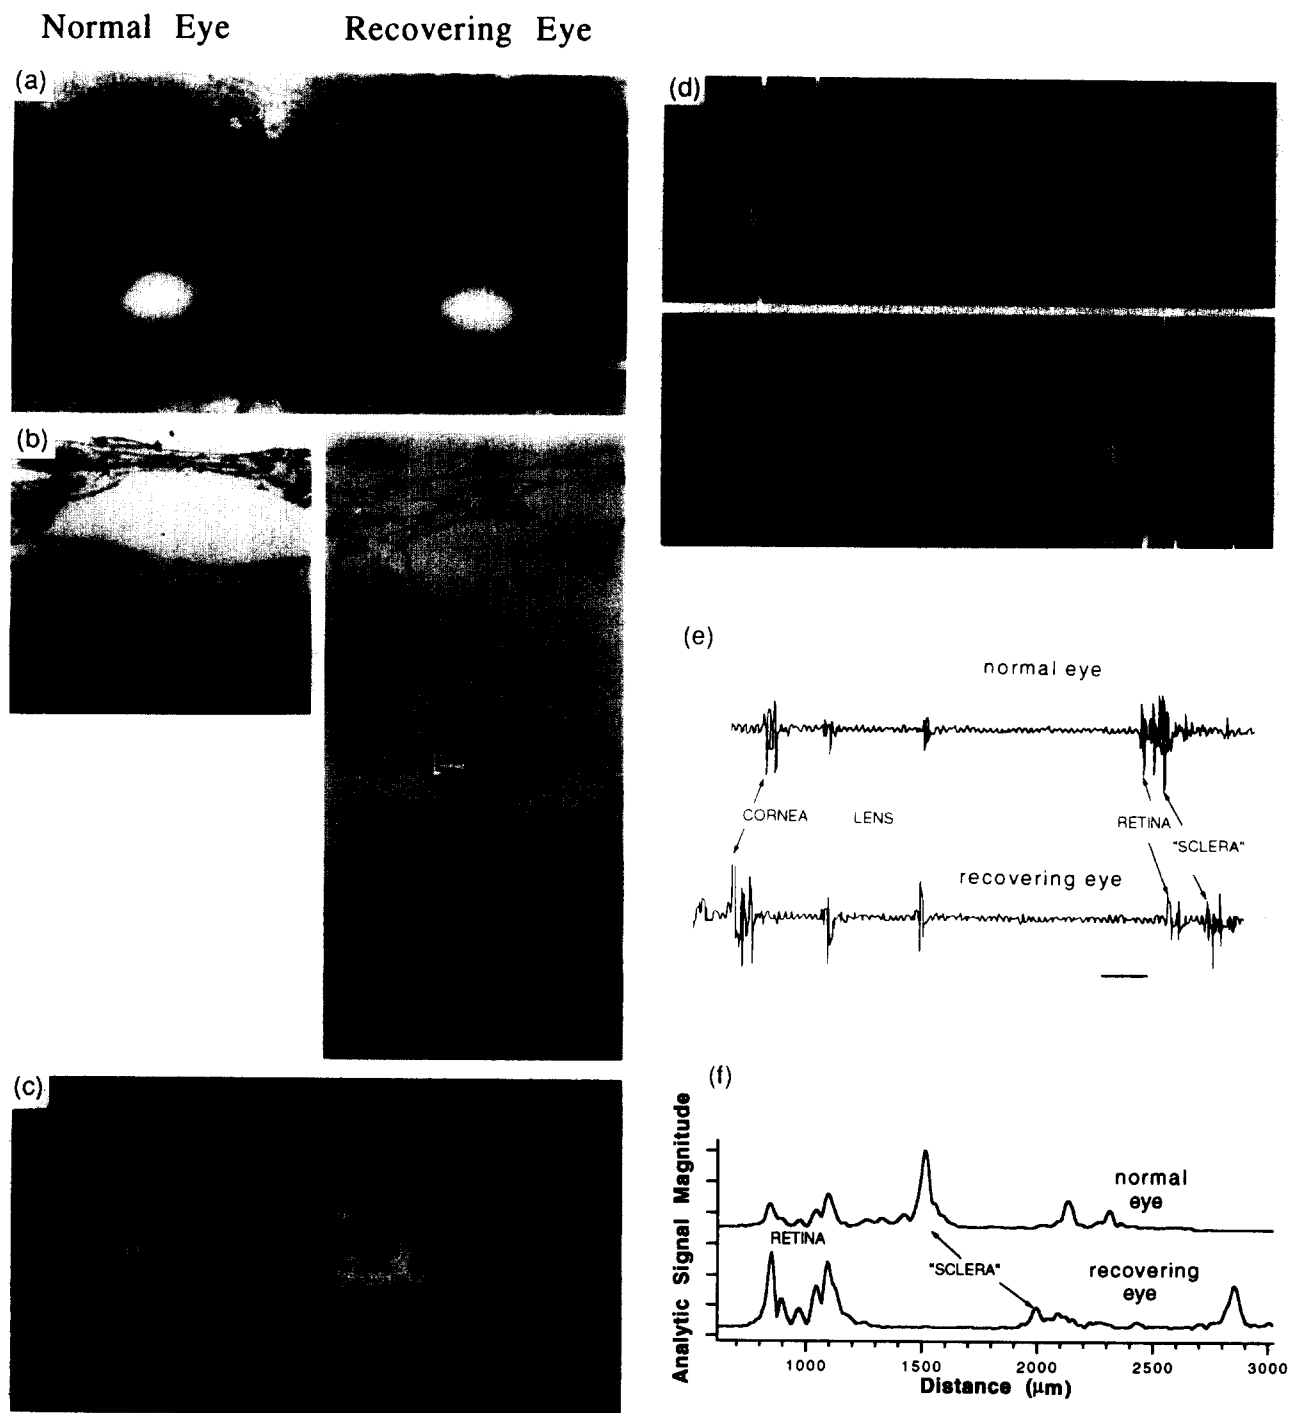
Choroidal expansion in eyes recovering from myopia induced by prior form-deprivation. In (a)–(c), recovering eyes are on the right, untreated fellow eyes are on the left. (a) Unfixed hemisected eyes. Arrowheads indicate choroidal boundaries. Scale bar, 2 mm. (b) Plastic-embedded sections at the posterior pole of eyes. Sclera begins just above pictures. L, lacuna; P, pigment cell; PE, retinal pigment epithelium; arrowhead indicates choriocapillaris. (c) One-mm-thick sections of the posterior eye wall. Ch, choroid, delimited by arrows; L, lacuna; R, retina. (d) High-frequency B-scan ultrasound image. R, retina; S, sclera; echo to left of retina is posterior lens surface. (e) Low-frequency A-scan ultrasound trace, representative of those used for measurements of thickness of “choroid + retina” in subsequent figures. Front and back lens peaks straddle the “lens” label. Scale bar, 2 μ sec. (f) High-frequency A-scan ultrasound trace, in which the analytic signal magnitude (Gammell, 1981) is plotted against distance.
